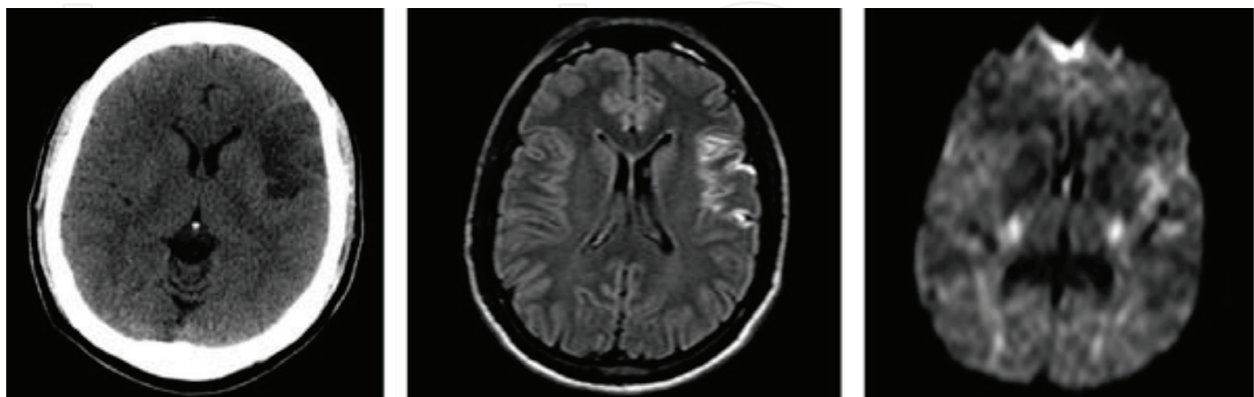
Cranial computed tomography, brain MRI (FLAIR-weighted), and brain diffusion MRI (DWI) showing, respectively, hypodense area in the left inferior frontal gyrus, hypersignal in the left anterior and posterior insular cortex, and restricted diffusion in the cortical region of the left insular topography, with sparing of the left angular and supramarginal gyri in a patient with transient Gerstmann syndrome [16].
